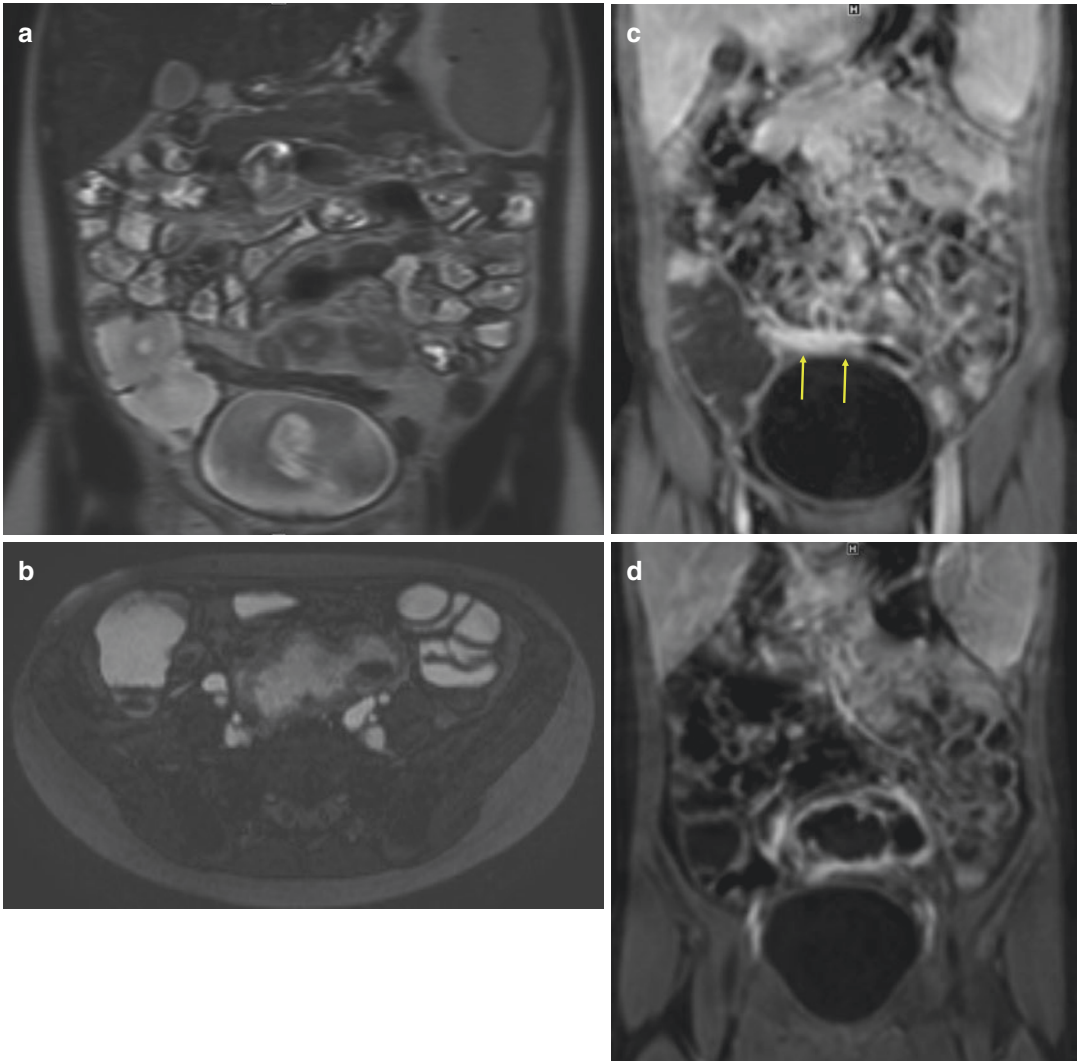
Eleven-year-old boy with active ileal CD. A large abscess has developed adjacent to a strictured ileal loop. (a) Coronal T2-weighted single-shot turbo spin-echo (SshSE) sequence demonstrating a collapsed and rigid ileal loop with discrete thickening of its wall above the bladder. (b) Axial balanced Turbo Field Echo (bTFE) sequence shows a large abscess collection located immediately above and behind the abnormal loop. (c) Coronal T1-weighted fat saturation after gadolinium injection
